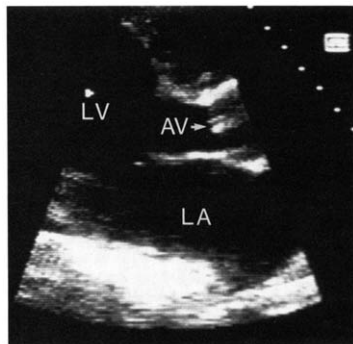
Infected aortic valve. Top panel. Transthoracic parasternal long-axis view in a patient with suspected infective endocarditis shows only nodular thickening of the aortic leaflet tip (AV). No mass distinct from the valve itself was seen. This echocardiographic study was rated as showing possible endocarditis. Bottom panel. Transesophageal image in the same patient. The valve demonstrates key features not evident on transthoracic study. 1) The leaflets appear normal near the annulus (making degenerative change unlikely); 2) the leaflet thickening (V) has soft tissue reflectance; and 3) a small portion of the mass prolapses into the left ventricular (LV) outflow tract. Diastolic fluttering of this thin extension of the mass was readily demonstrated. The distance between diagonal dots at the upper right of the image is 1 cm. This study was rated as showing almost certain endocarditis. RV = right ventricle; other abbreviations as in Figure 1.
